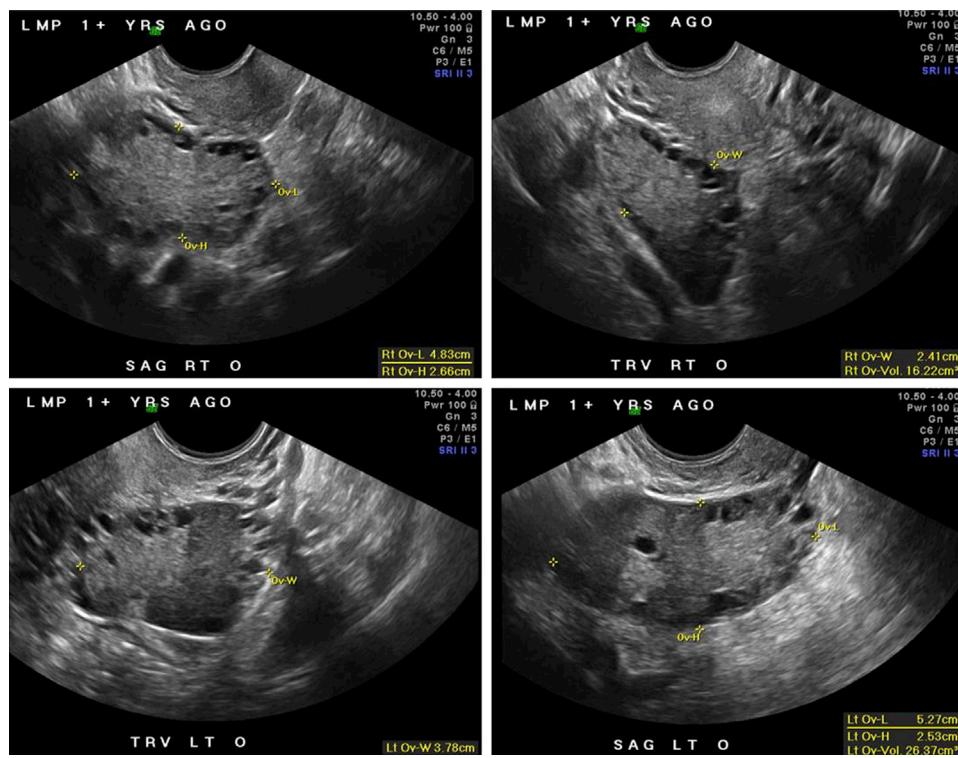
A transvaginal pelvic ultrasound scan reveals bilaterally enlarged ovaries with multiple small follicles of similar size along the periphery, which has a “string of pearls” appearance. The top 2 images show the right ovary (volume, 15 cc) in the sagittal and transverse views. The bottom 2 images show the left ovary (volume, 26 cc) in the sagittal and transverse views.
